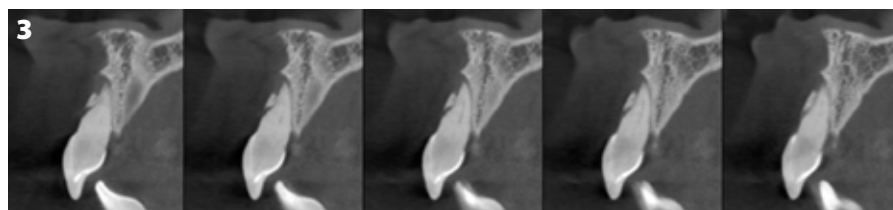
CBCT sagittal view of tooth 21. Notice the buccal dehiscence.
